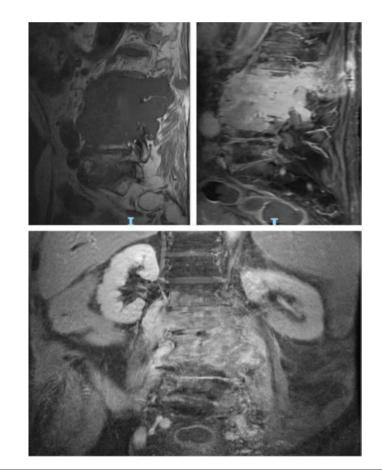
Repeat MRI scan of the lumbar spine after 8 weeks of anti-tuberculous therapy. Patient had worsening pain and bilateral proximal weakness in the lower limbs. There is also further spread to the posterior elements and ileo-psoas muscles. The patient underwent an extended open biopsy which confirmed the final diagnosis of metastatic desmoids melanoma.
